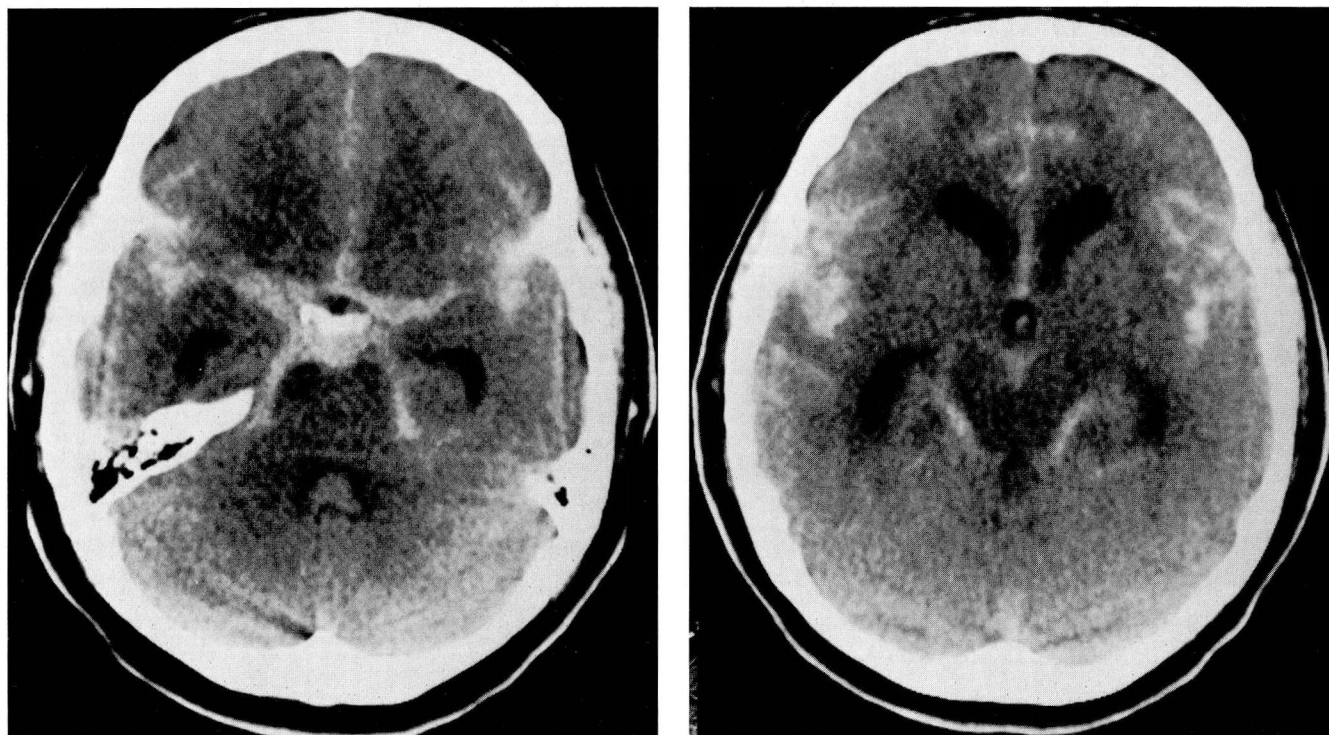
Computed tomographic images of the brain show a large amount of blood in the subarachnoid space and ventricular system following subarachnoid hemorrhage.
